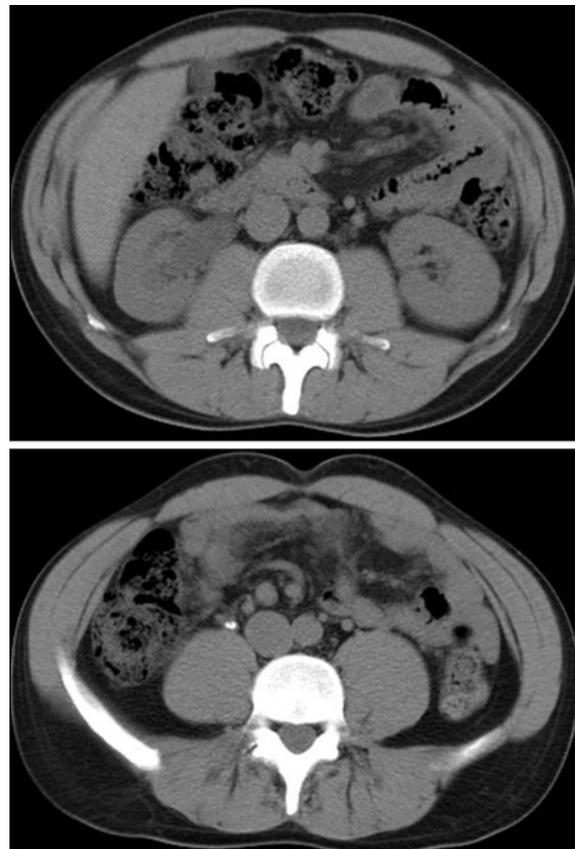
Urolithiasis. Axial CT sections, without intravenous contrast material, at the levels of the kidneys and the ureteral abdominal tract. Multiplanar coronal reconstruction performed with low-dose technique show a right hydro-uretero-nephrosis with evidence of an obstructing calculus located at the level of the ureteral abdominal portion
